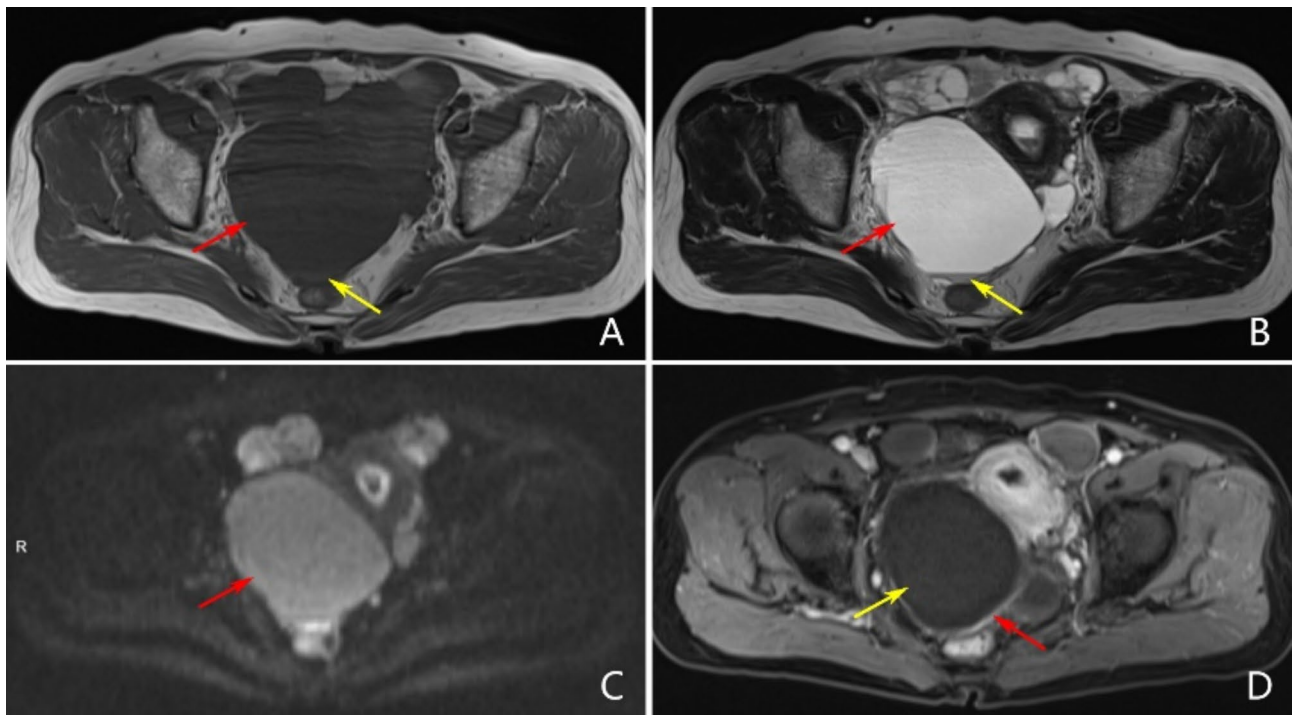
Patient 9, presented with lower abdominal pain for 5 days, clinically and pathologically confirmed as AGCT-NEL, FIGO stage IIIA. (A) T₁WI axial view: A unilocular cystic mass is observed in the right adnexa, well-defined, appearing hypointense on T₁WI (red arrow), with homogeneous signal and the presence of a hemorrhagic fluid level, which appears slightly hyperintense (yellow arrow). (B) T₂WI axial view: The mass exhibits very high signal intensity (red arrow), and a hemorrhagic fluid level is visible (yellow arrow). (C) DWI sequence: The mass shows slightly elevated signal intensity (red arrow). (D) Axial view post-contrast scan: The wall of the mass shows marked enhancement (red arrow), while the contents of the cyst do not exhibit enhancement (yellow arrow)
